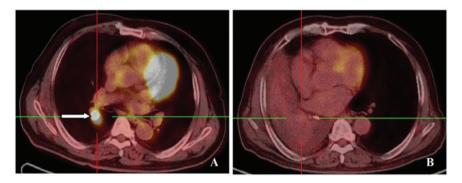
Thoracic PET-CT scan of a 77-year-old man with adenocarcinoma of the right lung. (A) Prior to radiotherapy; (B) 7 months after radiotherapy and 6 months after gefitinib initiation (obstructive atelectasis in the right lobe with no FDG metabolism). White arrow, location of tumor. PET-CT, Positron emission tomography computed tomography; FDG, fluorodeoxyglucose.
